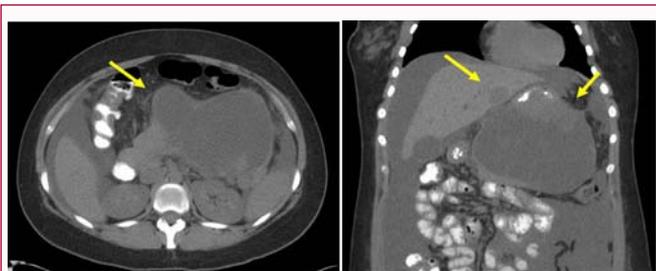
CT scan showed a 15 × 13 × 11 cm complex heterogeneous mass, apparently originating from the body of the pancreas and protruding into the gastric wall, and metastatic lesion in the liver.
